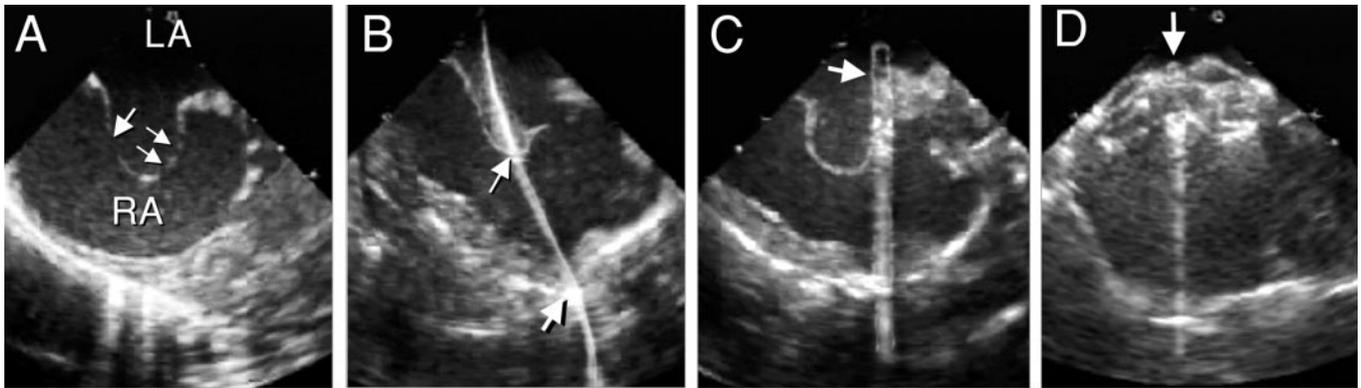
Closure with a peratrial atrial septal defect (ASD) closure device in a 4-month-old infant with a large multifenestrated ASD and anterior muscular ventricular septal defect. A, A transesophageal echocardiogram in the longitudinal plane demonstrating the presence of a large atrial septal aneurysm with a large superior defect (large arrow). B, Peratrial puncture (arrow) and passage of a wire through a hole created with an aortic punch. C, The sheath tip is positioned in the left atrium. D, Repeat image in the same plane after the deployment of an 11-mm Amplatzer septal occluder and demonstrating good device position and elimination of the aneurysm.
